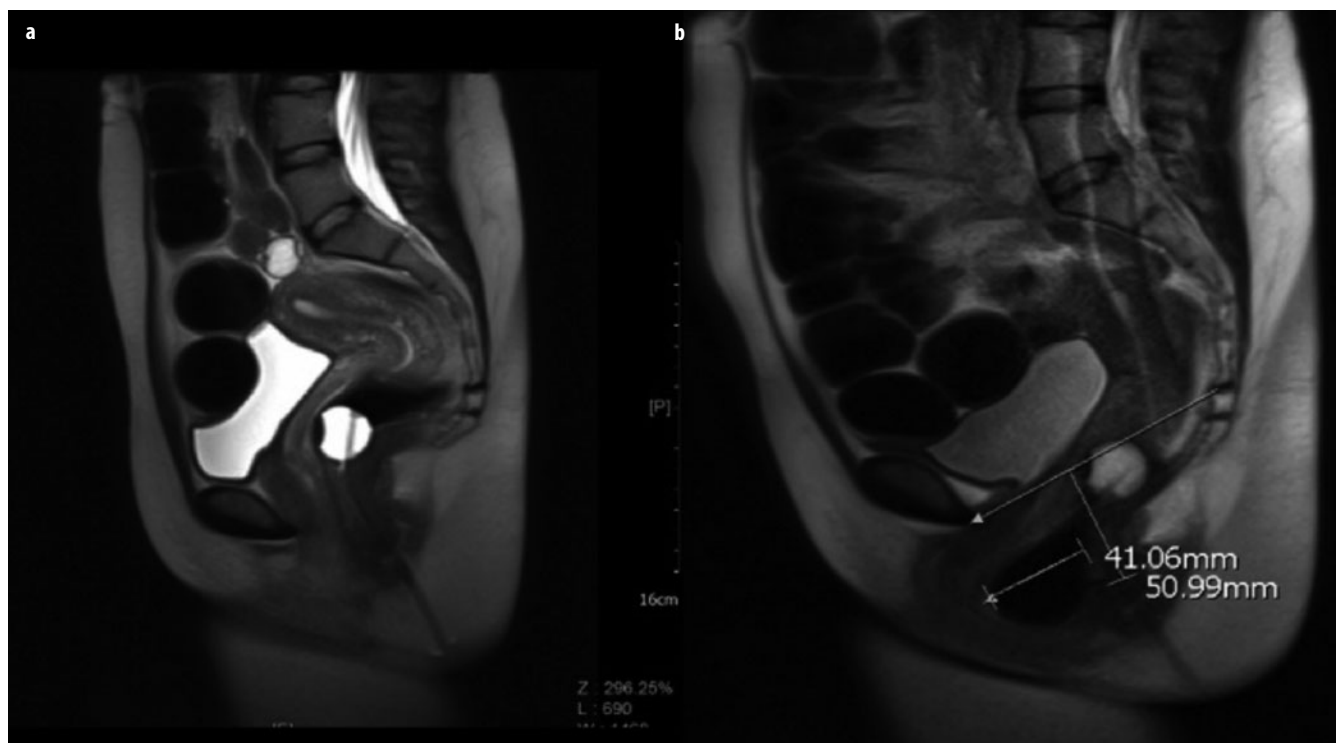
a, b. Rectocele. a Sagittal T2-weighted image at rest after rectal filling with air through a balloon catheter. b During straining, a large anterior rectocele develops (>4 cm) and is associated with prolapsed anorectal junction (ARJ) (>5 cm)
